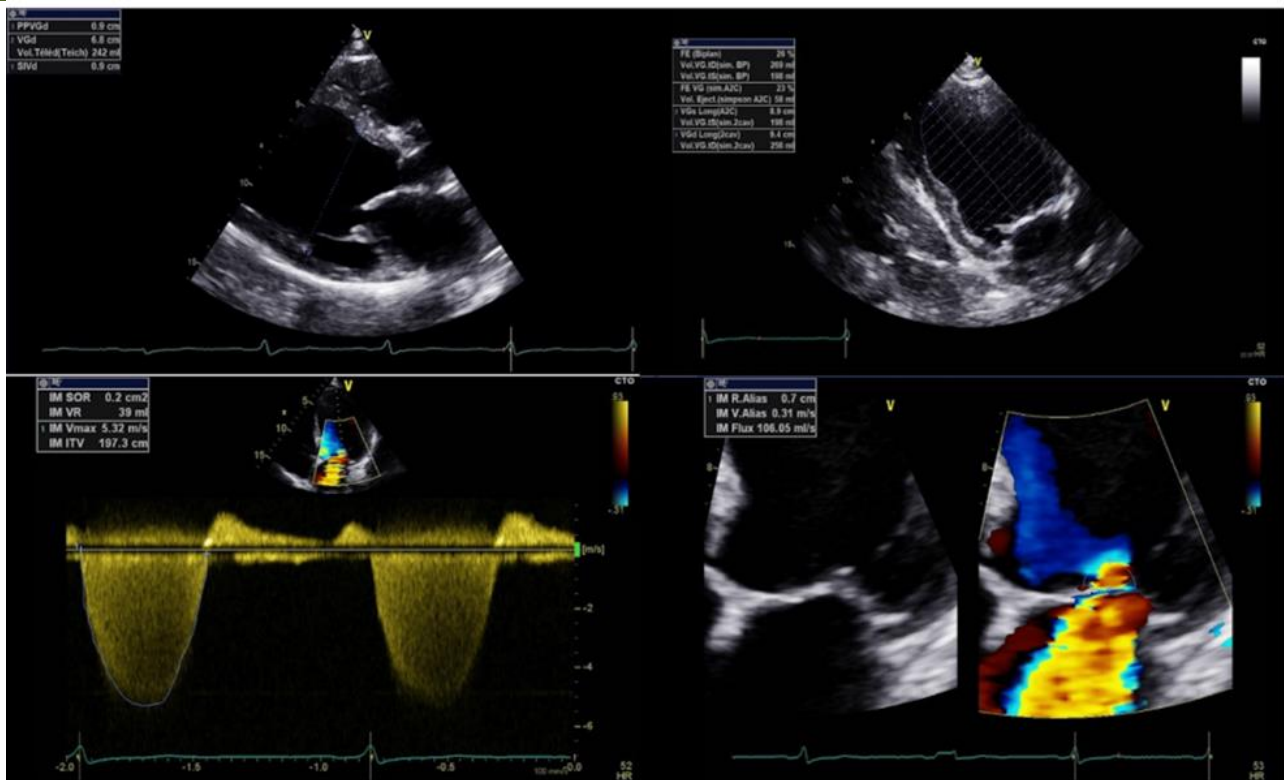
Echocardiography showing a dilated left ventricle with severe global systolic dysfunction (LVEF of 26%) and moderate secondary mitral insufficiency
